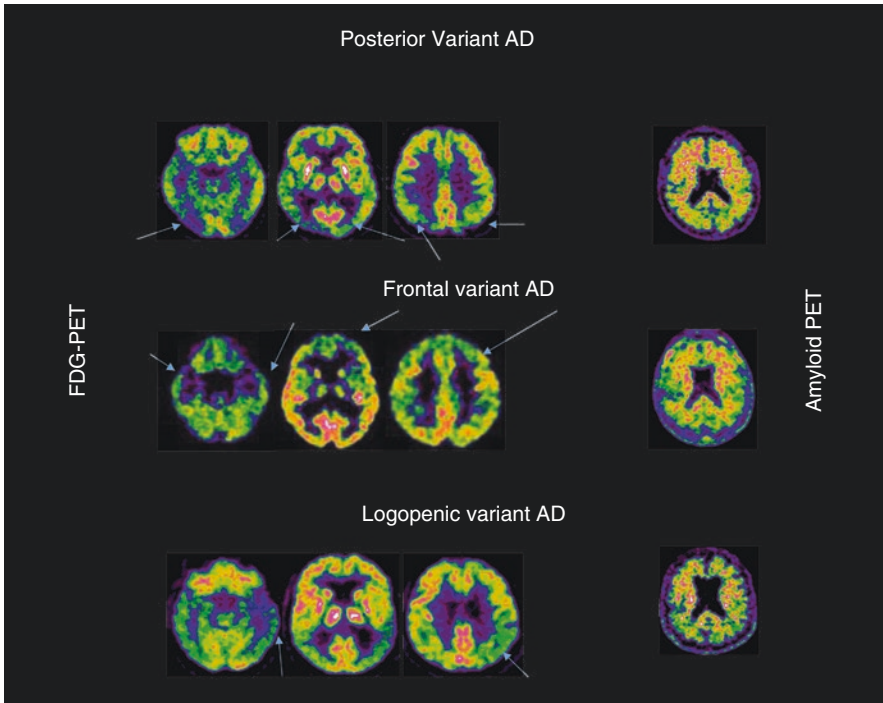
FDG-PET and amyloid PET findings in AD atypical variants. Each AD atypical variant is characterized by a specific pattern of hypometabolism (light blue arrows; see the main text for further details). All these variants are characterized by high amyloid deposition and are thus amyloid PET positive (right panel showing lack of contrast between gray and white matter uptake in the amyloid PET scans of all patients)
